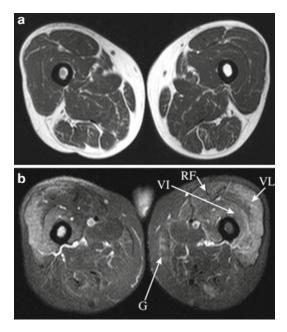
Same patient as in Fig 26.13 with dermatomyositis. (a) Axial T1-weighted MRI scans of the upper leg show no signs of fatty infiltration. (b) Fat-suppressed T2-weighted images of the upper leg with more-or-less symmetrical edematous changes, compatible with inflammation, in the rectus femoris (*RF*), vastus intermedius (*VI*), vastus lateralis (*VL*), and gracilis (*G*) muscles
